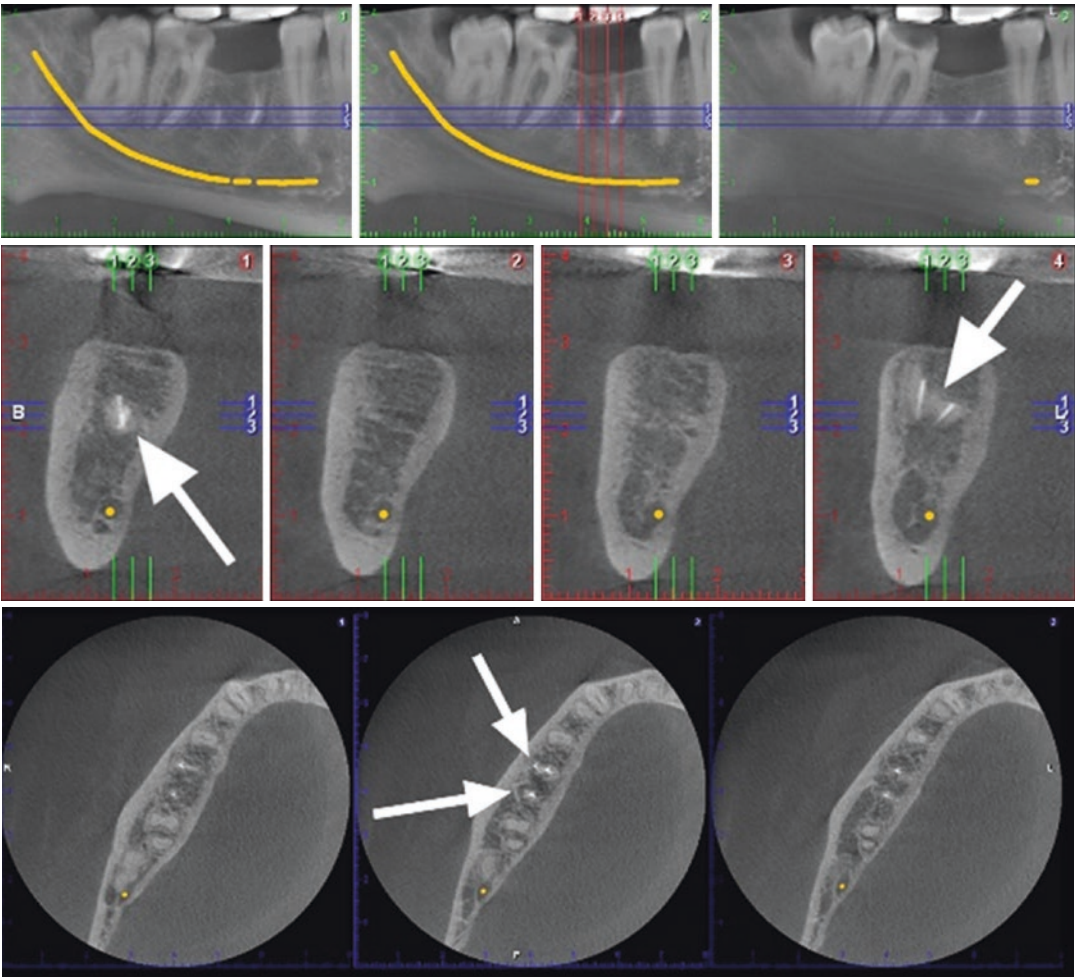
CBCT taken with a small FoV. A small portion of the mandible can be assessed. Thus, image quality is improved and radiation dose is reduced
